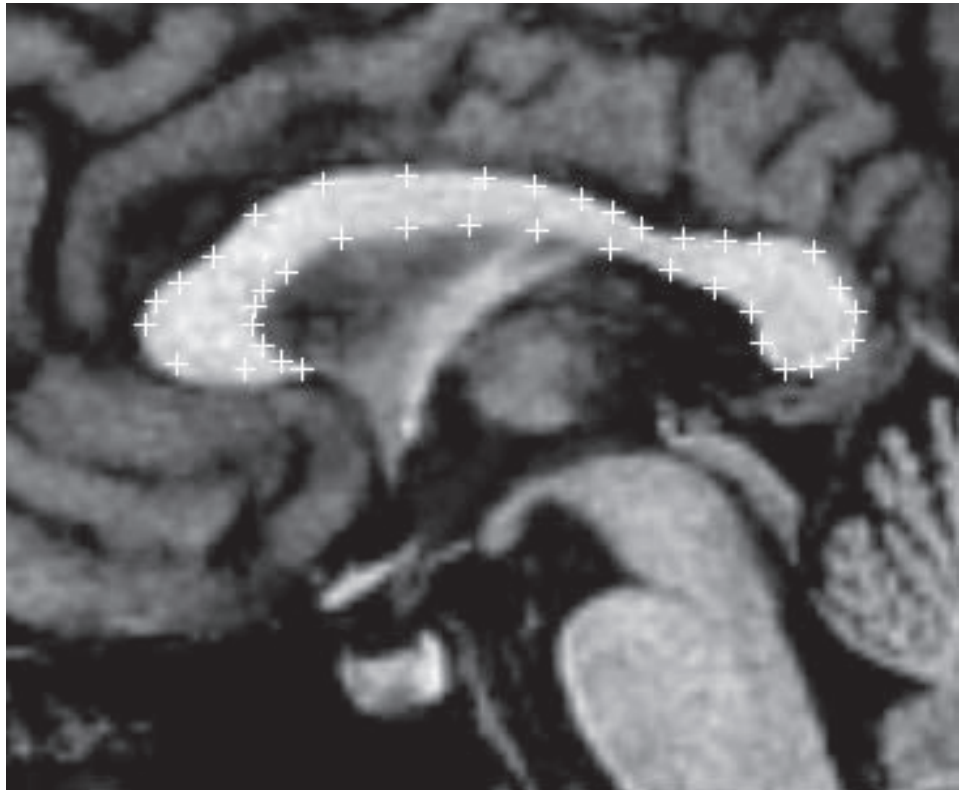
The callosal midcurve of defendant XX as visualized over a nearby plane of his MRI scan³
